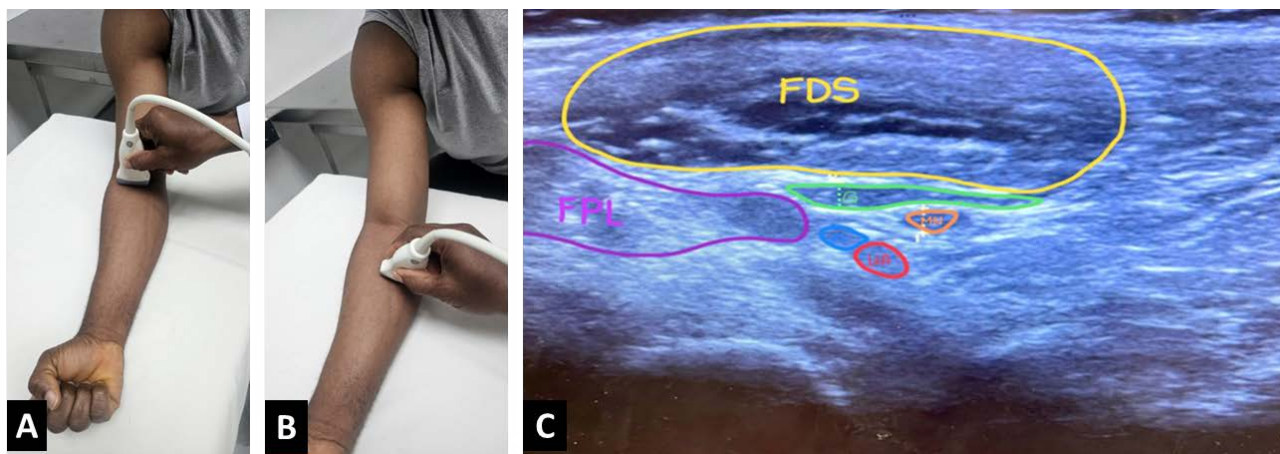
Ultrasound examination of Gantzer's muscle (GM). (A) Probe positioning during active finger flexion to assess dynamic changes. (B) Probe positioning with the forearm at Rest. (C) Annotated ultrasound image demonstrating relevant anatomical structures: flexor digitorum superficialis (FDS), flexor pollicis longus (FPL), Gantzer's muscle (G/GM), median nerve (MN), ulnar vein (UV), and ulnar artery (UA).
